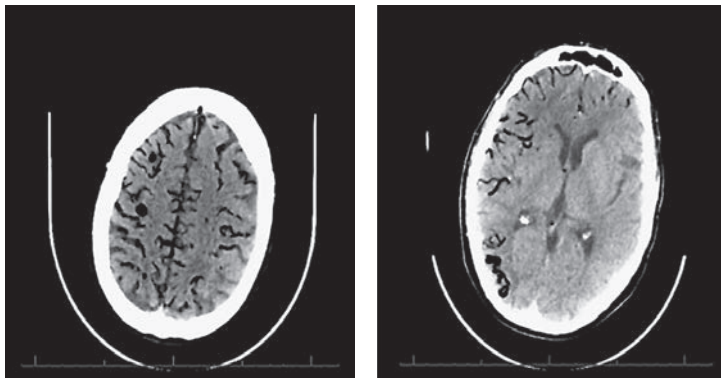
Computed tomography of head showing extensive air in the vascular territory overlying both cerebral hemispheres. Gas is seen predominantly within the cerebral veins, superior sagittal sinus and right cavernous sinus. Several pockets of gas are seen in the right frontal region which may represent gas within focally dilated cerebral veins or adjacent sulci.
